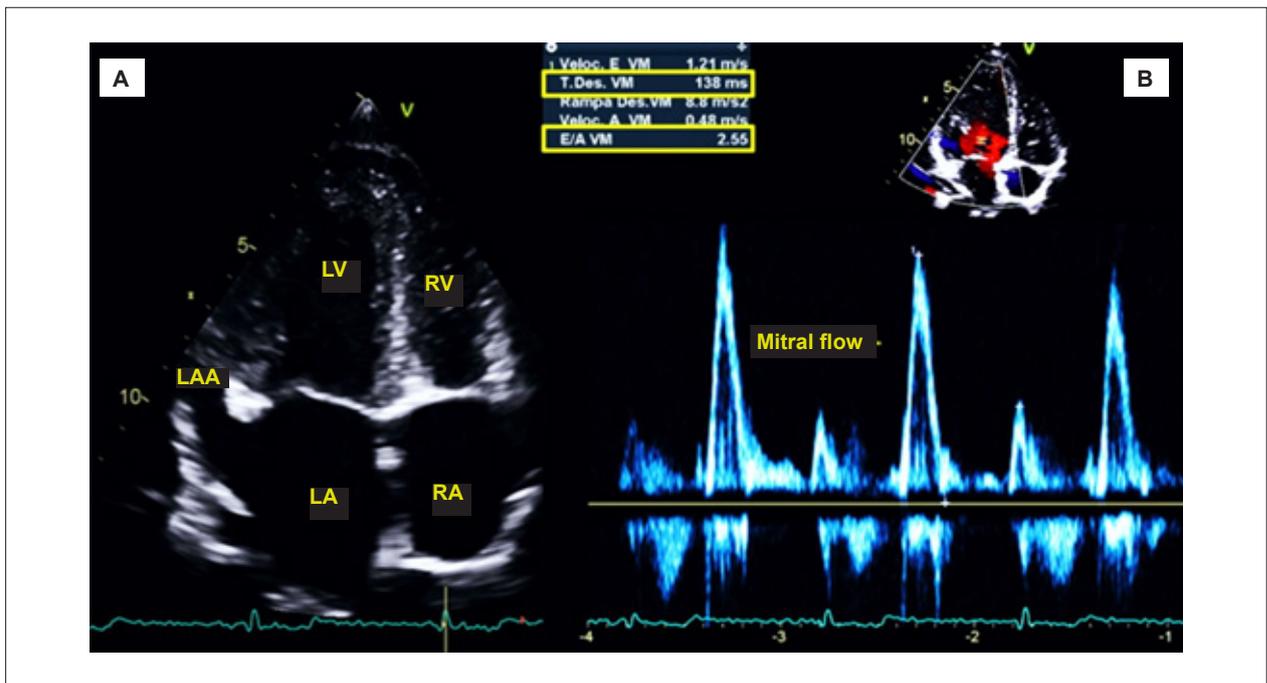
Left: Apical four-chamber view on 2D echo. Right: Doppler mitral flow on a young athlete. LAA: left atrial appendage; RA: right atrium; LA: left atrium; E/A VM: mitral valve E/A ratio; T.Des. VM: mitral valve deceleration; RV: right ventricle; LV: left ventricle..
